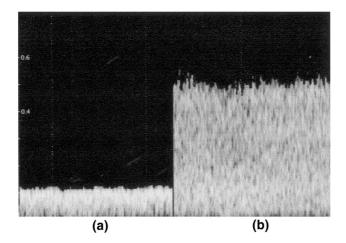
Doppler recording in a fetus of 17 weeks gestation showing a typical low blood velocity in the vein of the umbilical cord (a) and a high velocity at the umbilical ring in the abdominal wall (b). The velocity increment is attributed to the tightening of the umbilical ring during the second trimester. Duration of each recording: 1 s; velocity scale: m/s.
